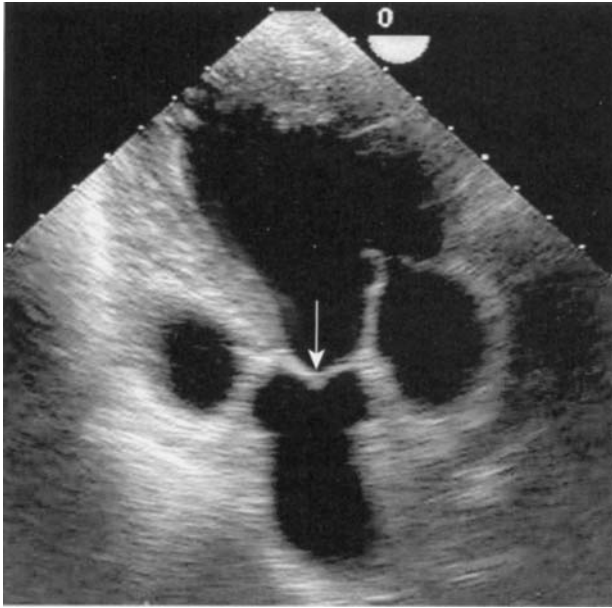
Deep transgastric long-axis view of the aortic valve; multiplane angle 0° . The arrow indicates the point of coaptation of the aortic valve cusps. This view is developed by advancing the TOE probe deep into the stomach and flexing the tip anteriorly and to the patient's left. It is most useful for making spectral Doppler measurements of aortic valve flow.
